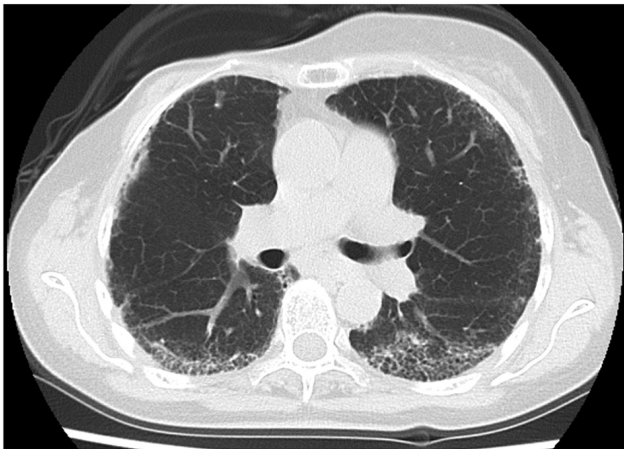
No progression of ground-glass shadows in the peripheral lower lobes of both lungs were seen on chest computed tomography compared with before treatment for scleroderma-associated interstitial lung disease.
